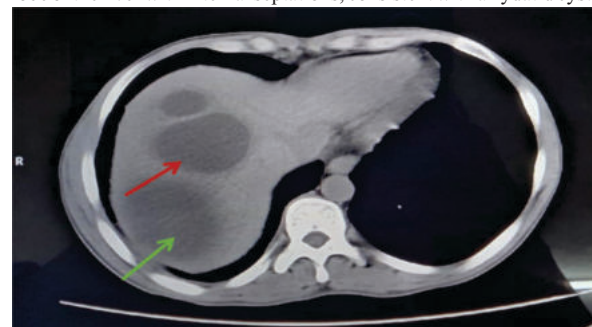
Contrast-enhanced CT scan showing right lobe hydatid cysts of variable sizes (Red and Green)
